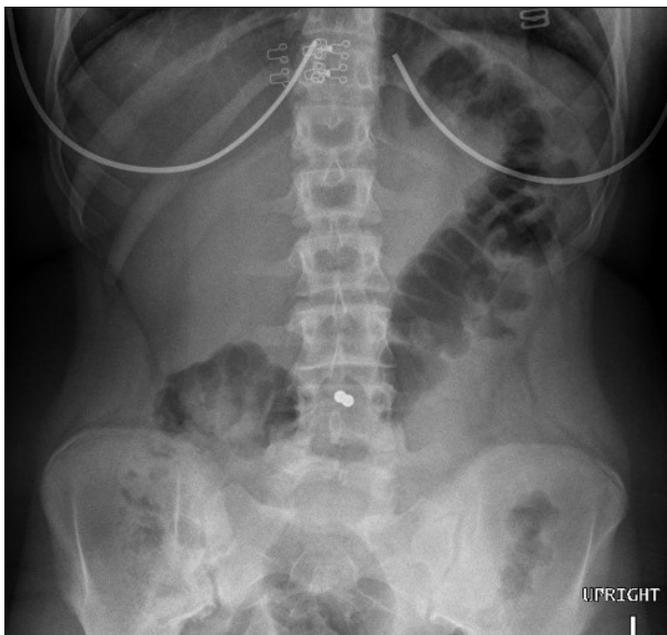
Abdominal x-ray showing 2 radiopaque objects in the mid-abdomen.
